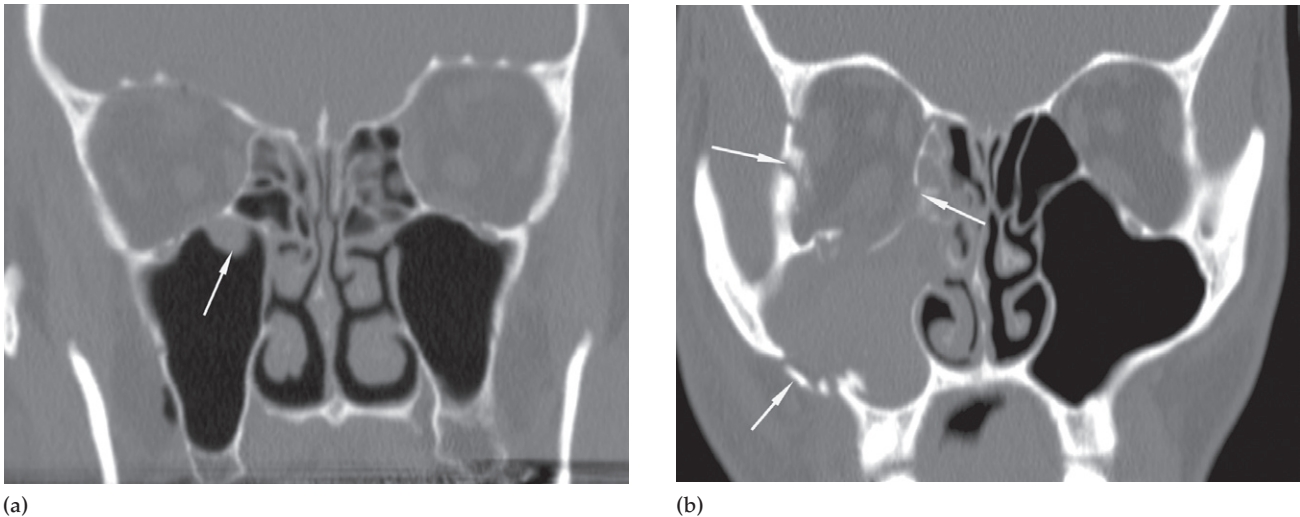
Blowout fracture of the orbit; CT coronal reconstruction. (a) A patient with a blow to the eye showing a soft tissue opacity in the roof of the antrum (arrow). It is difficult to appreciate the fracture of the orbital floor. (b) A patient with trauma to the side of the face showing disruption of the floor of the orbit and fractures of the lateral and medial walls of the orbit, as well as the lateral wall of the antrum (arrows). There is herniation of orbital contents into the antrum, which is opaque.
